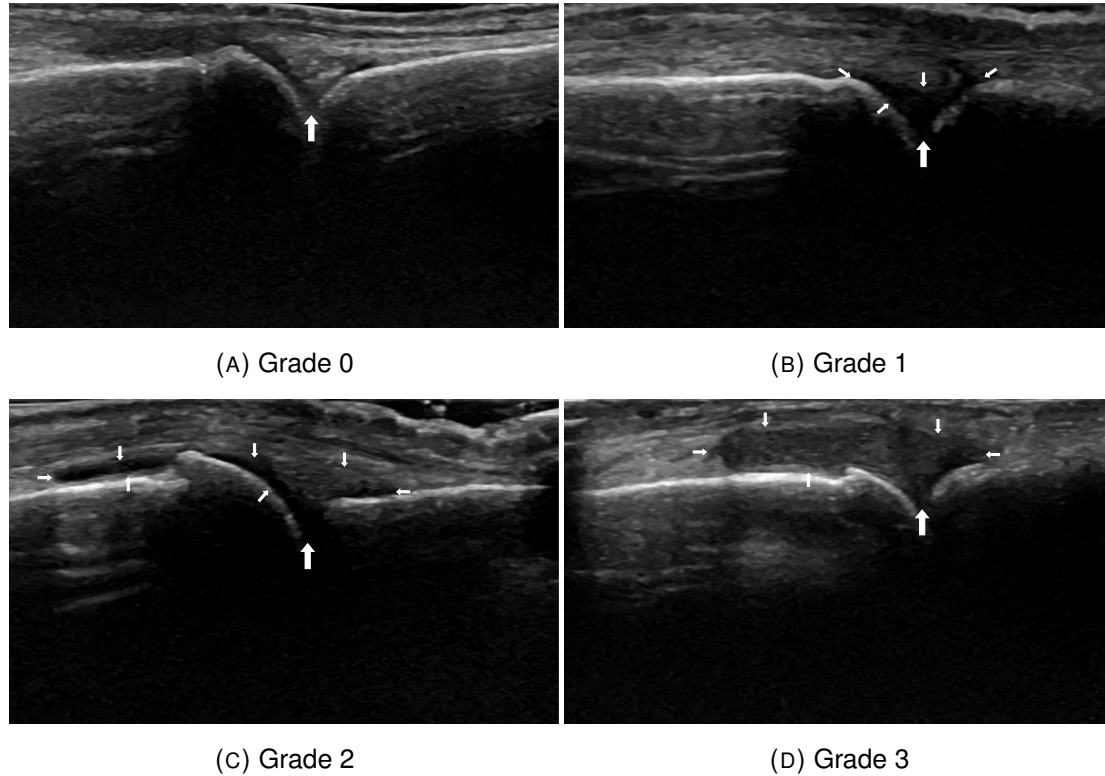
Example of ultrasound images of the second MCPJ with different joint capsules aspects and synovitis grades. Small arrows indicate the joint capsule extension and big arrow indicates the joint.
